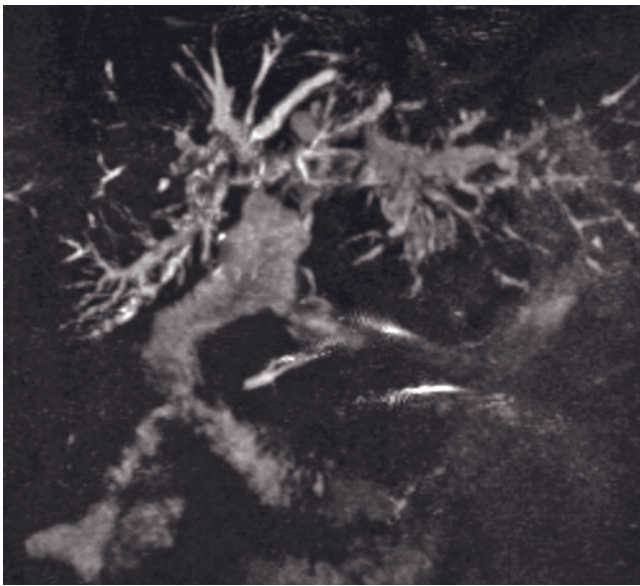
Biliary anastomosis. Coronal T2-weighted fat-suppressed thin-section MRCP image (a) in a patient with hepaticoporto-enterostomy (after Kasai operation) showing the normal anastomosis between a bowel loop and the porta hepatis (arrow). Intrahepatic nondilated bile ducts are also well depicted (thin arrow). Paracoronaral T2-weighted fat-suppressed thick-section MRCP image (b) and thin-section MRCP images (c, d) in a different patient with hepaticojejunostomy after liver transplantation. The thick-slab MRCP image (b) gives an excellent overview of the anatomic situation. The biliary anastomosis (long arrow, b-d) between the common hepatic duct and the jejunal bowel loop (asterisk, b; curved arrow, c, d) shows normal diameter and regular fluid signal. The intrahepatic bile ducts are mildly dilated, and the right and left hepatic ducts (short arrows, c, d) are well visualized. The remaining original common bile duct (arrowhead, b) and the adjacent pancreatic duct are also visualized. T2-weighted coronal
